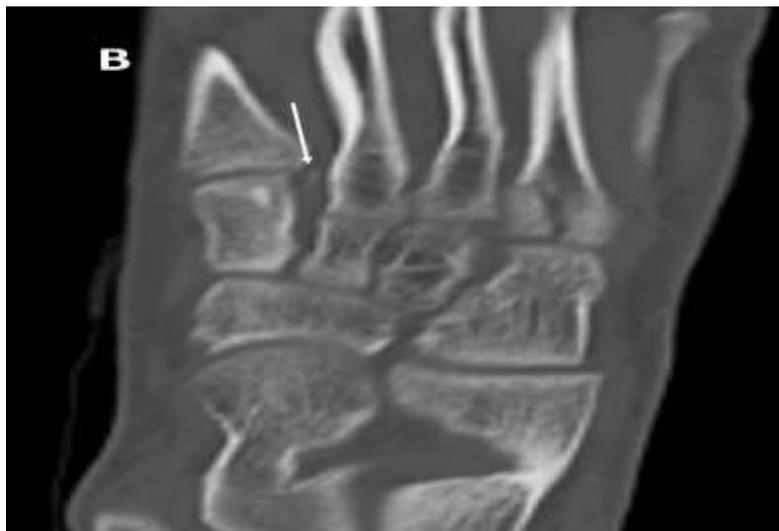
Patient number 8 in table 1, A: Anteroposterior radiograph of the left foot showing widening of the distance between the medial cuneiform and second metatarsal. B: CT scan showing the increased distance and the bone shin indicating Lisfranc ligament injury (arrow). C: Intraoperative fluoroscopy showing the increased distance between the medial cuneiform and middle cuneiform (arrows) with the stress applied by Senn retractor indicating the extension of the ligamentous injury proximally. Intraoperative, no instability was found in the first MT joint. D: Fixation construct performed based on the pathology affected.
